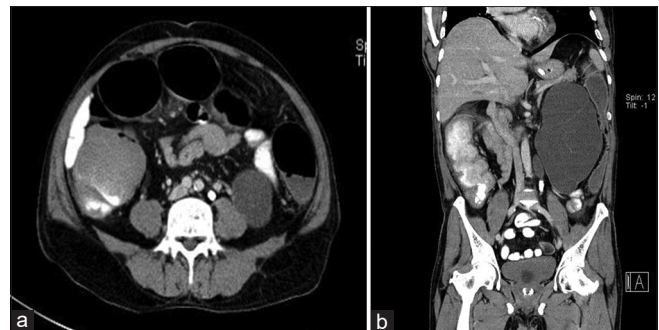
(a and b) Axial and coronal reconstruction of contrast-enhanced computed tomography abdomen shows a calculus in the left upper ureter causing gross hydronephrosis of the left kidney
